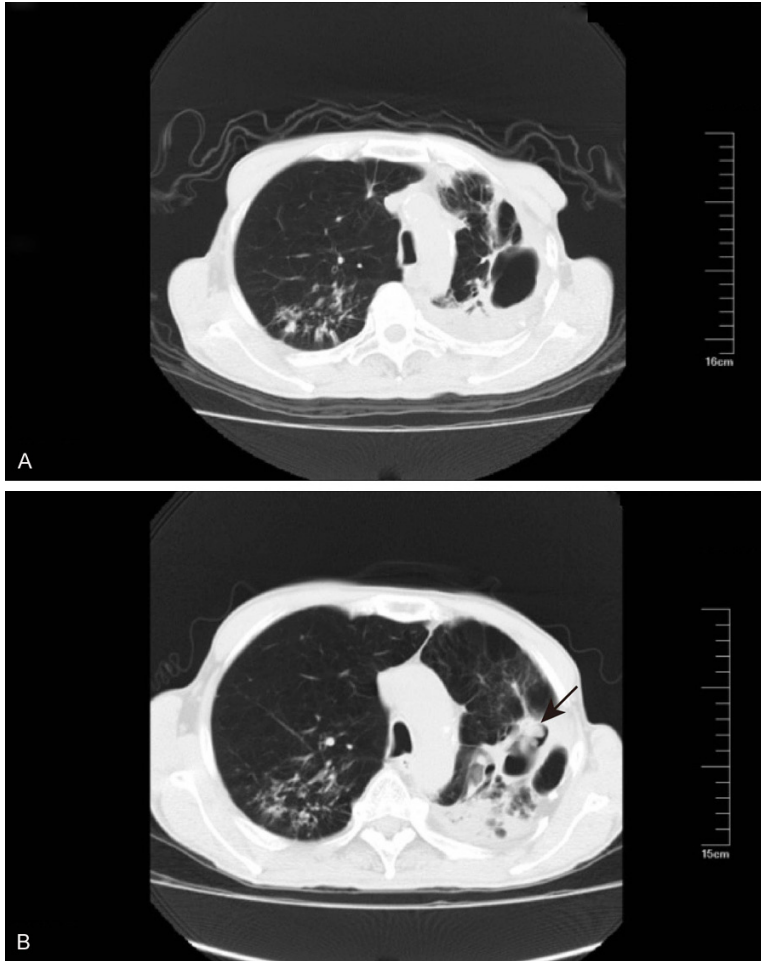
Computed tomography (CT) of this patient at 6 months ago (A) and at present (B). Black arrow indicated PPCA.
